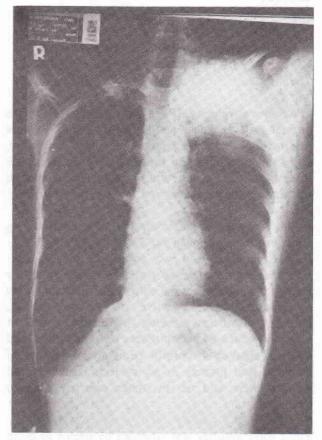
X-ray appearance of the case, show a mass in the left clavicula, which already infiltrated to left intra thoracic space
